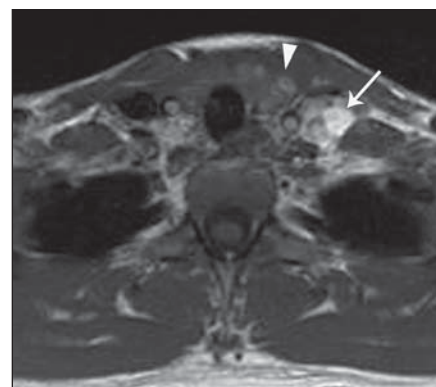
24-year-old woman with papillary thyroid carcinoma and nodal metastases that are intrinsically hyperintense on T1-weighted imaging. This medical student presented with several-month history of hoarseness for which she had been treated elsewhere with thyroplasty for left vocal cord paralysis.
